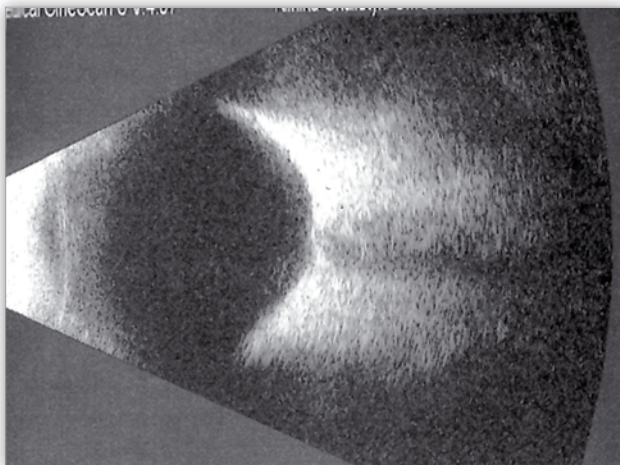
Ultrasound of the left eye.
